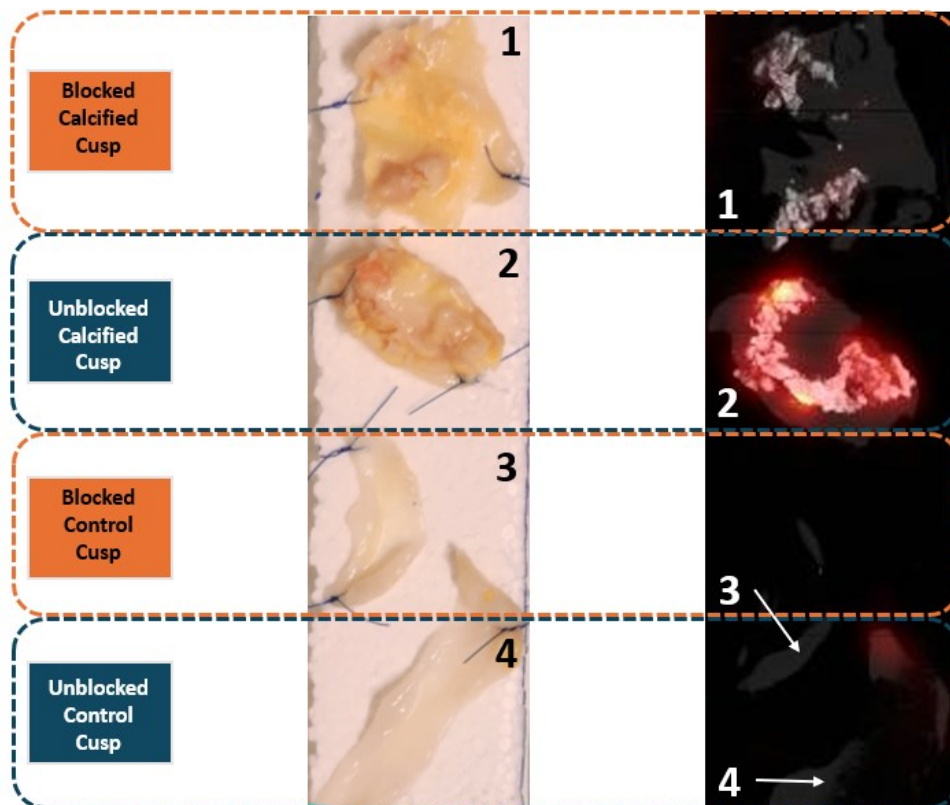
Examples of four valves imaged ex vivo by PET-CT. The top two valves are stenotic calcified valves, while the bottom two are control valves (homografts). Prior to incubation with ^{18}F -NaF, two valves (calcified valve 1 and control valve 3) were saturated with unlabeled NaF tracer. The specificity of ^{18}F -NaF labeling was clearly demonstrated, as no uptake was observed in the two valves previously blocked by unlabeled NaF. In contrast, a distinct tracer uptake signal was observed in the non-blocked valves
